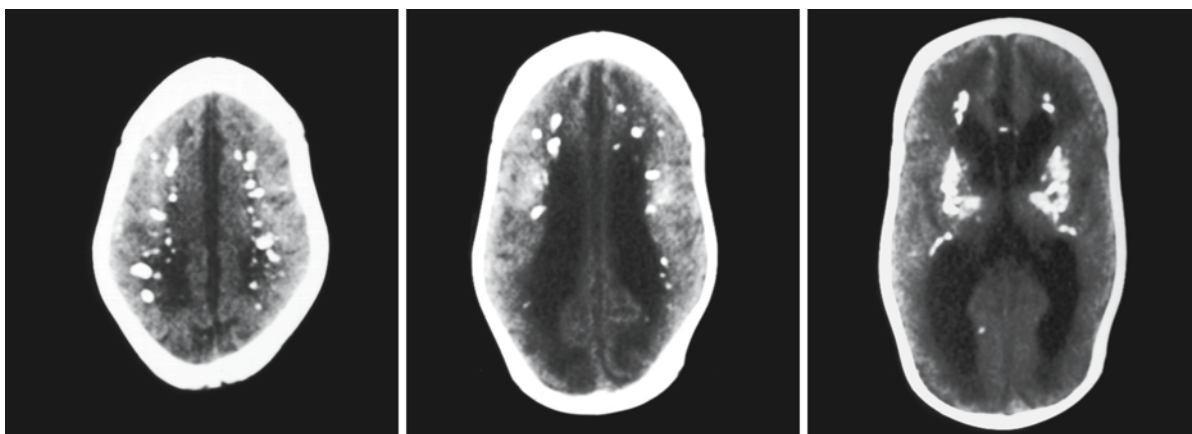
CT of a 4-month-old patient with Aicardi–Goutières syndrome, demonstrating how extensive the calcium deposits may be. Courtesy of P.G. Barth, Department of Child Neurology, Academic Medical Center, Amsterdam, The Netherlands
